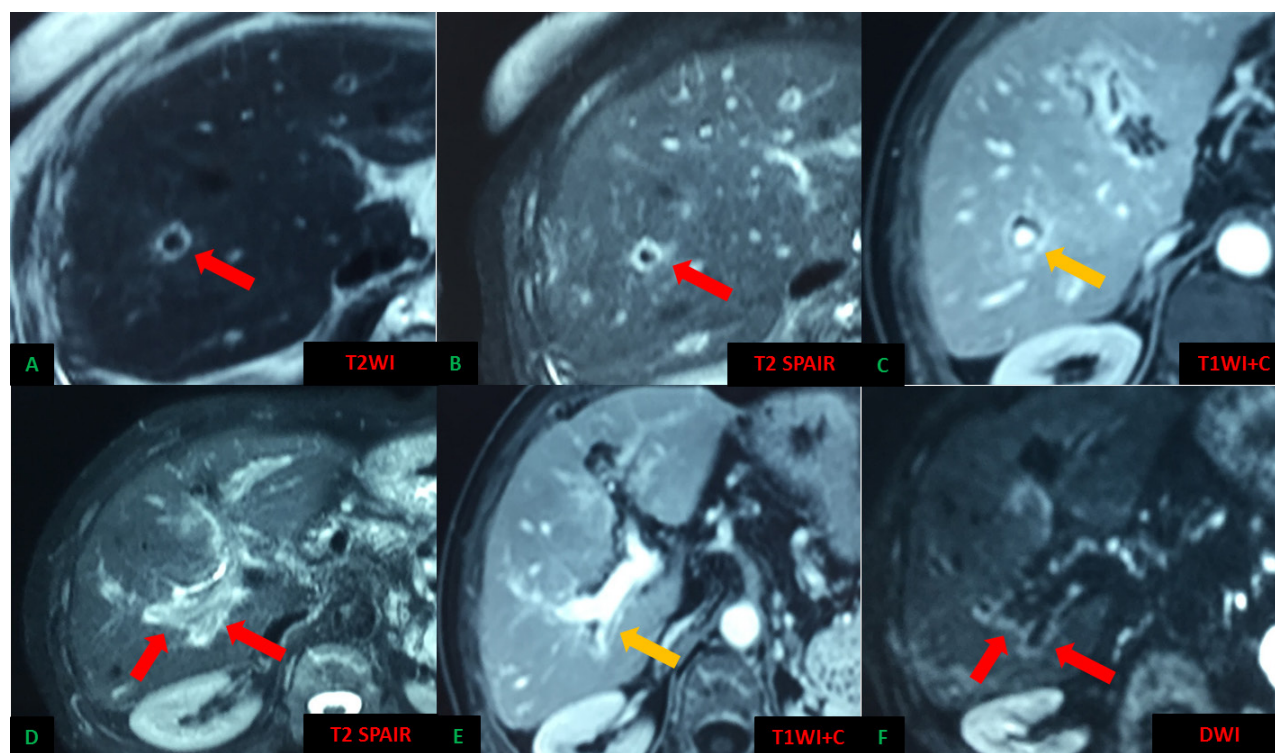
Periportal halo hyperintensity on T2WI, fat-saturated T2WI and DWI (red arrows in A, B, D and F images respectively) and linear periportal enhancement on post-contrast T1WI in a 75-year old woman with autoimmune hepatitis (yellow arrows in C and E).
